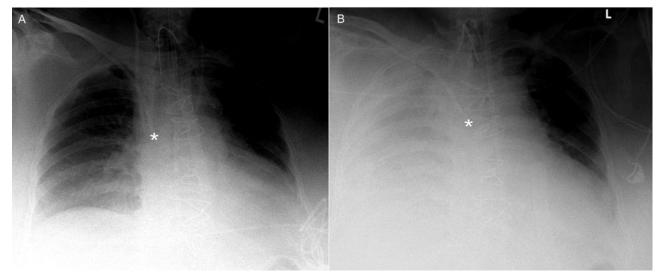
A: Initial anterior-posterior chest x-ray in supine position. The central venous lines project in correct position on the superior vena cava. No pneumothorax or relevant pleural effusion can be found. Additionally, the tracheostomy tube and nasal tube can be seen. B: Follow-up chest x-ray after respiratory deterioration, showing progressive opacity of the right hemithorax. The tip of the central venous catheter inserted via the right subclavian vein is retracted, compared to the previous chest x-ray.
